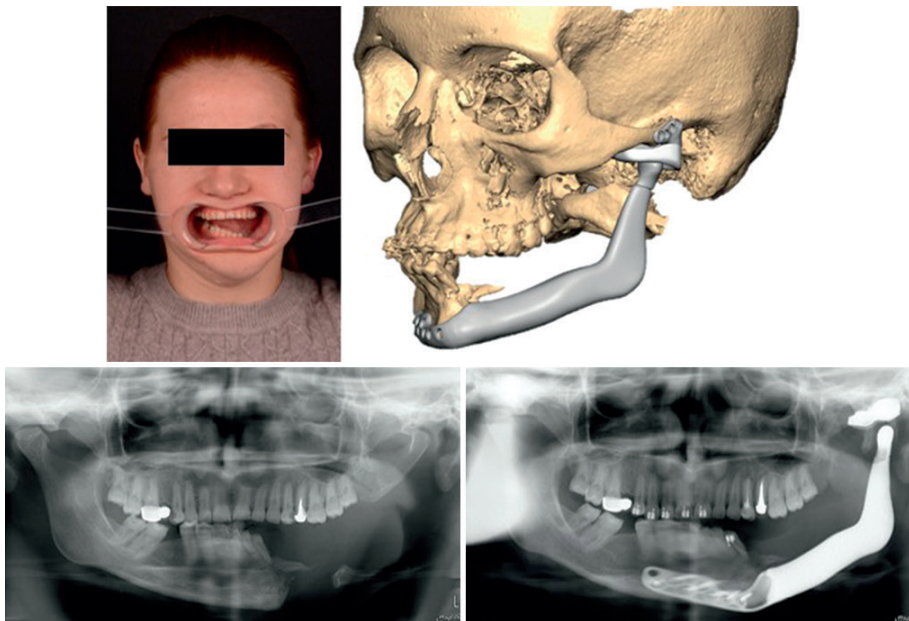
Case # 5. (a) Preoperative facial frontal view with open mouth. (b) Surface tessellation language render of the planned extended temporomandibular joint replacement. (c) Orthopantomogram showing the preoperative occlusion and left-sided mandibular defect. (d) Orthopantomogram showing the postoperative occlusion and extended temporomandibular joint replacement *in situ*
